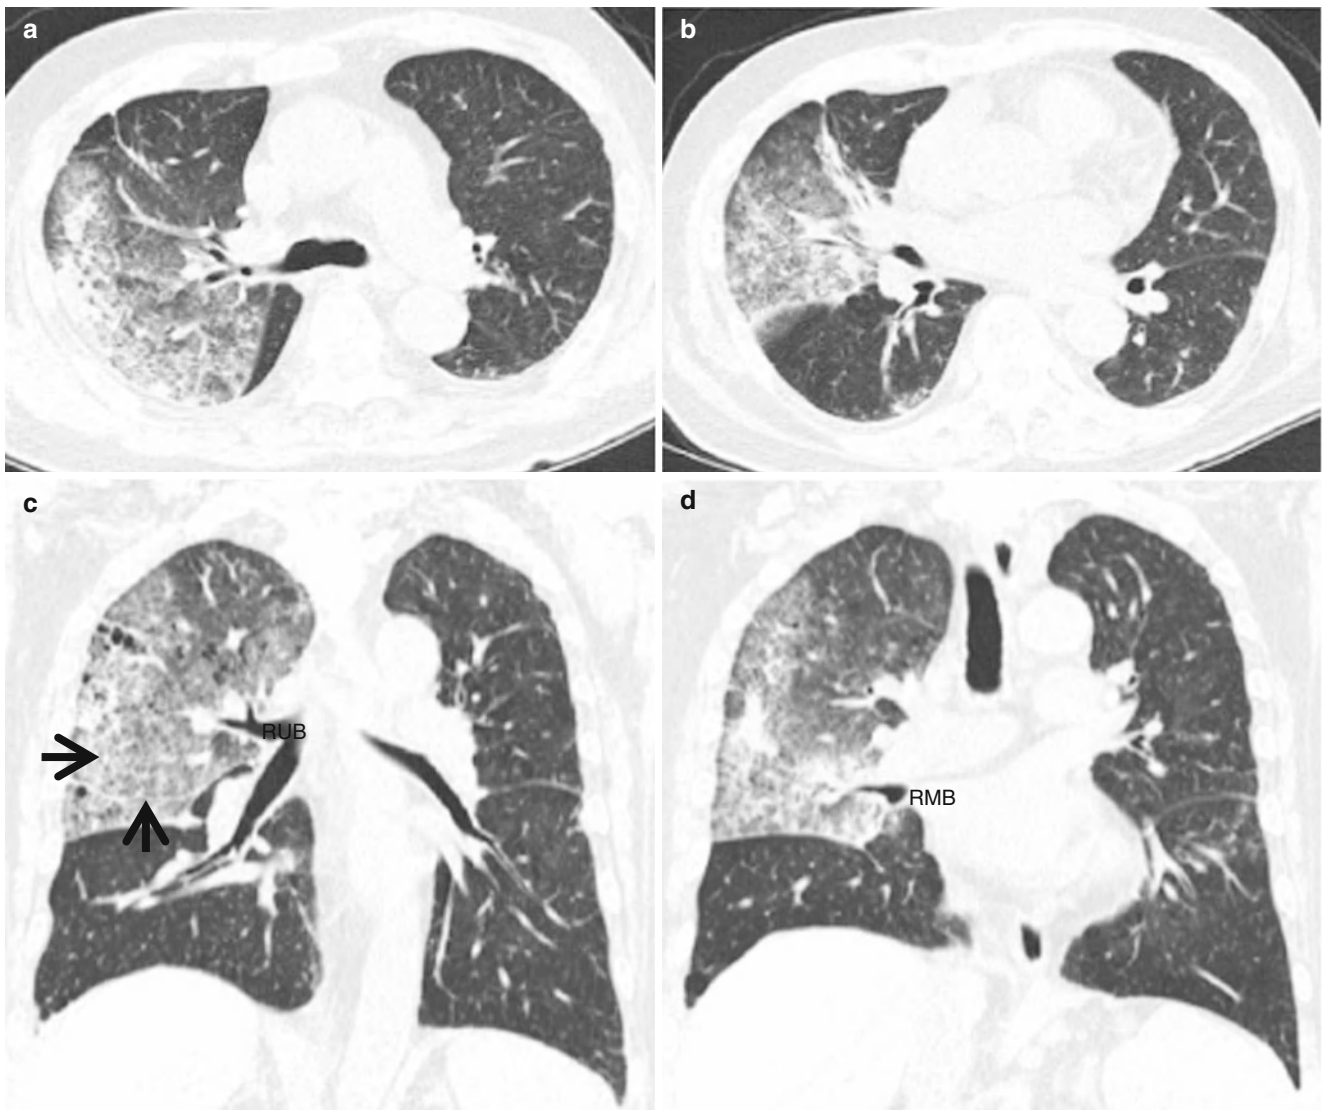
Lobar pneumonia in a 74-year-old man with acute myeloid leukemia and neutropenic fever. Urine culture disclosed gram-positive cocci. (a, b) Thin-section (2.5-mm section thickness) CT scans at levels of the right upper (a) and middle lobar (b) bronchi, respectively, show lobar parenchymal opacity involving the right upper and middle lobes.
